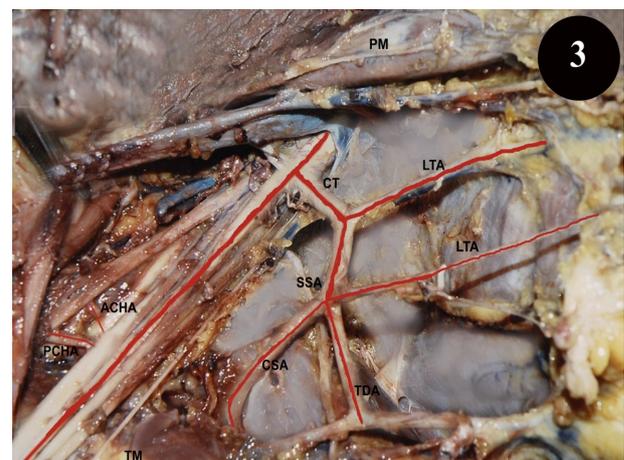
Showing common trunk (CT) for Lateral thoracic artery (LTA) and Thoracodorsal artery (TDA).
